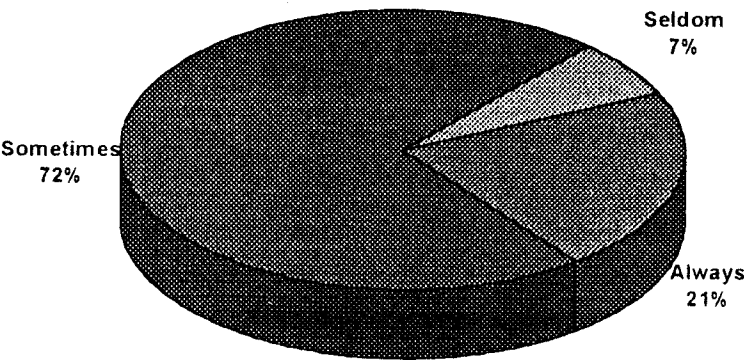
Use of radiographs in the diagnosis of caries
